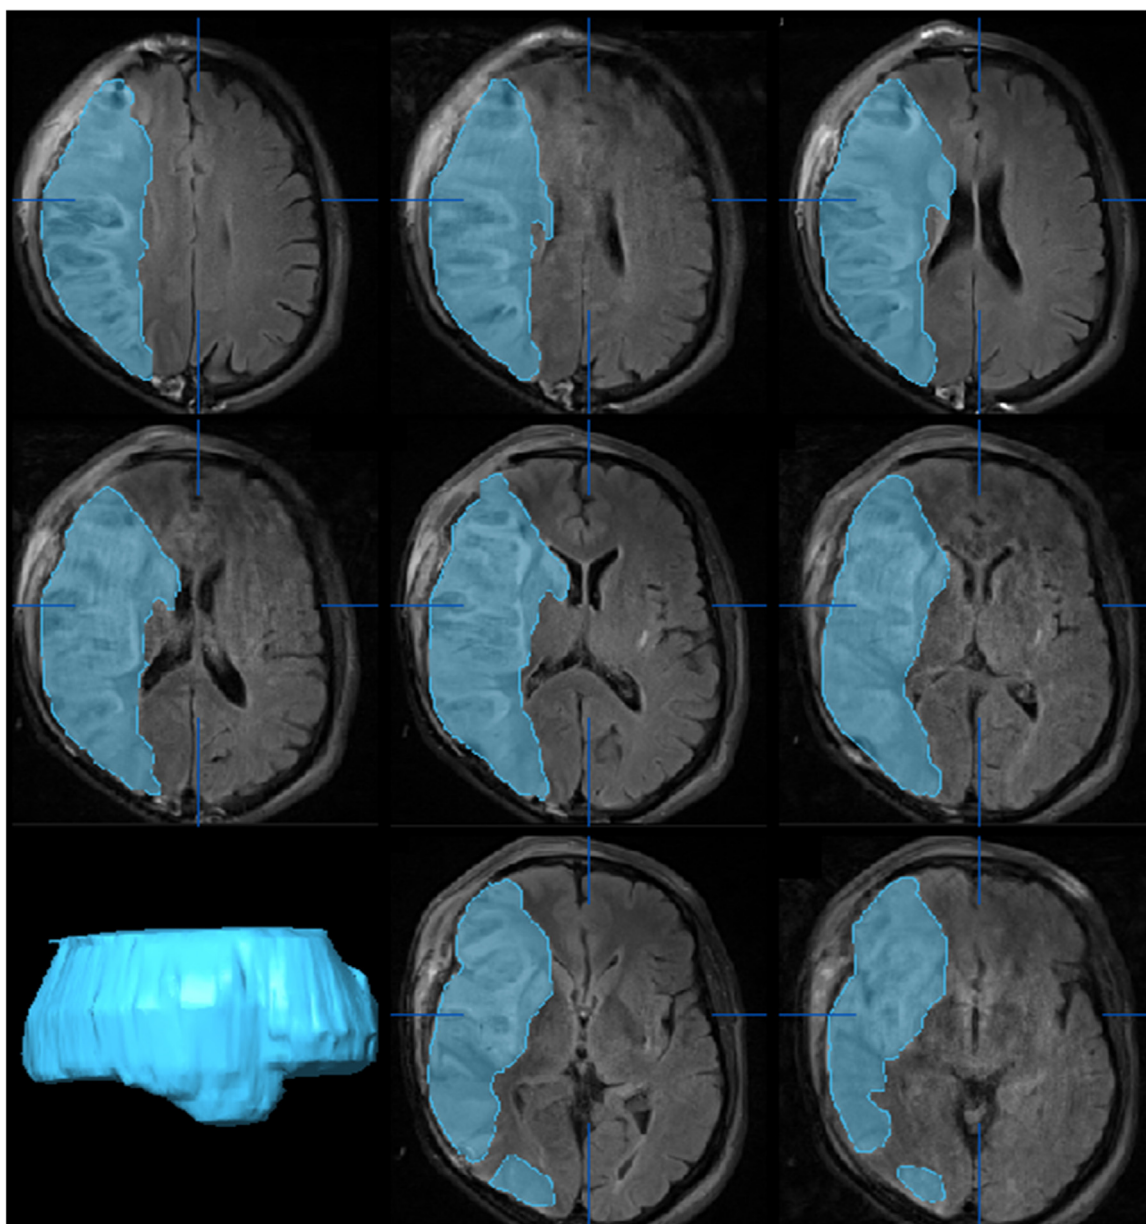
Preoperative MRI scan showing a large right sided malignant middle cerebral artery infarction (grey).
